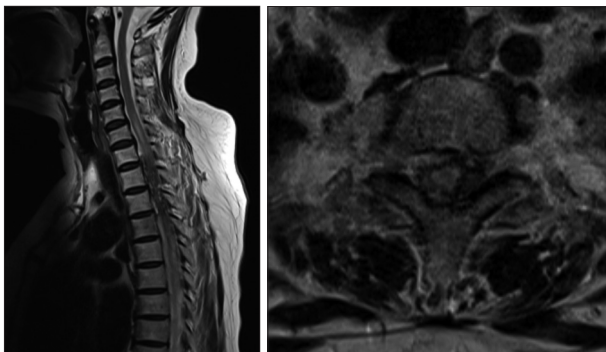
Thoracic T2-weighted MRI showing intradural extramedullary low signal intensity at the T2–3 levels, consistent with spinal subarachnoid hematomas, and high spinal cord signal intensity from C5 to T4.
